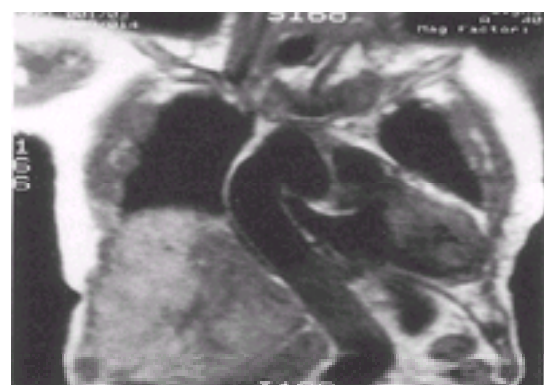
MRI scan after thromboexclusion procedure; the ascending abdominal aortic graft is clearly seen.
